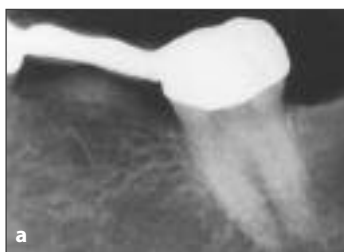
Case 1. Periapical radiograph exhibiting a mixed mottled radiopaque and radiolucent sclerotic mass under a hygienic pontic in the area of the mandibular left first molar, with a thin radiolucent line separating the mass from the alveolar crestal bone.
